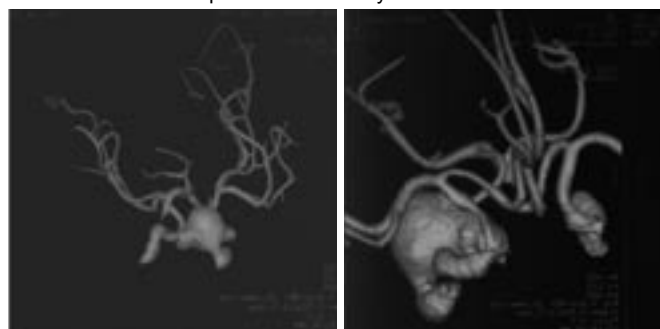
CT angiography with 3D VRT images revealing giant aneurysm in the cavernous portion of the left internal carotid artery.
